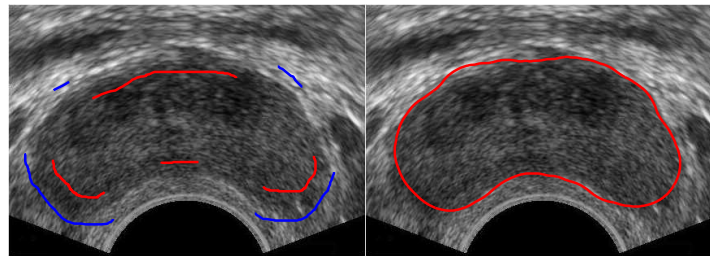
Prostate segmented from the transrectal ultrasound image.
